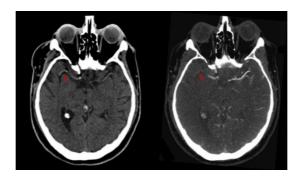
NCCT and CTA scans of the brain of an acute ischemic stroke patient. Red arrows display the site of the occlusion.
